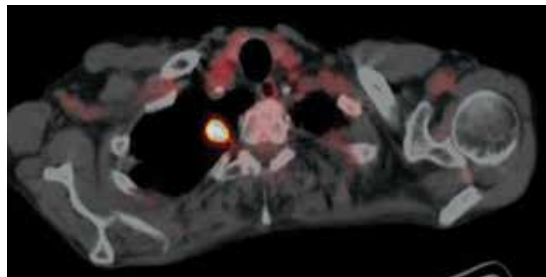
PET image of the right lung, in the area of adenocarcinoma and at the sites of microinvasive endobronchial squamous cell carcinoma. PET slices through right and left upper lobe were negative for FDG uptake.
